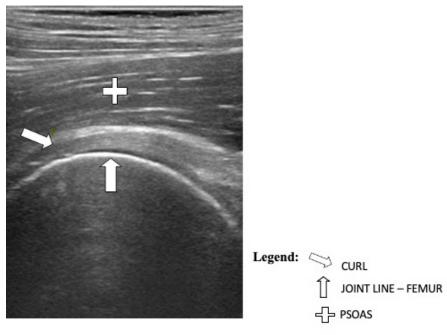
Hip, capsular ultrasound reference line.
